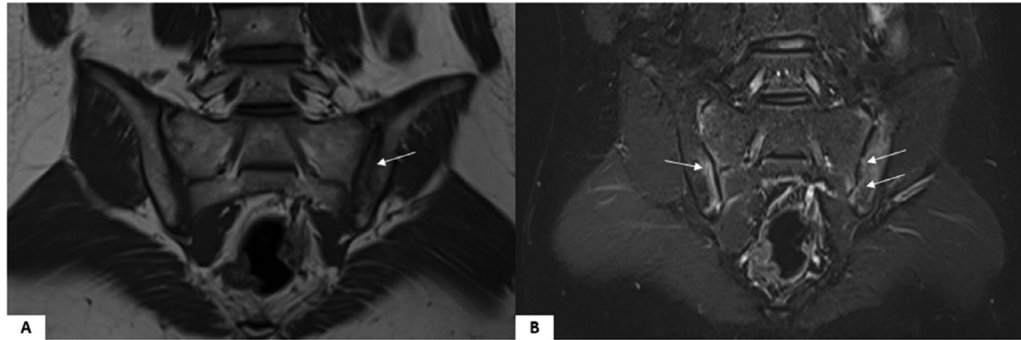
Magnetic resonance imaging of the sacroiliac joint. (A) Bone marrow edema appears as a hypointense signal on T1-weighted images. (B) Bone marrow edema appears as a hyperintense signal on short tau inversion recovery images.
